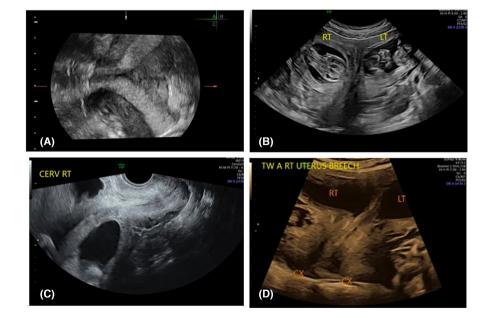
(A) Prepregnancy, transvaginal ultrasound with 3D reconstruction, (B) 12 weeks 2 days, transabdominal ultrasound, transverse image demonstrating two uterine cavities, (C) 12 weeks 2 days, transvaginal ultrasound, right cervix clearly visualized, (D) 18 weeks 2 days, transabdominal ultrasound, two uterine cavities with corresponding left and right cervices.
